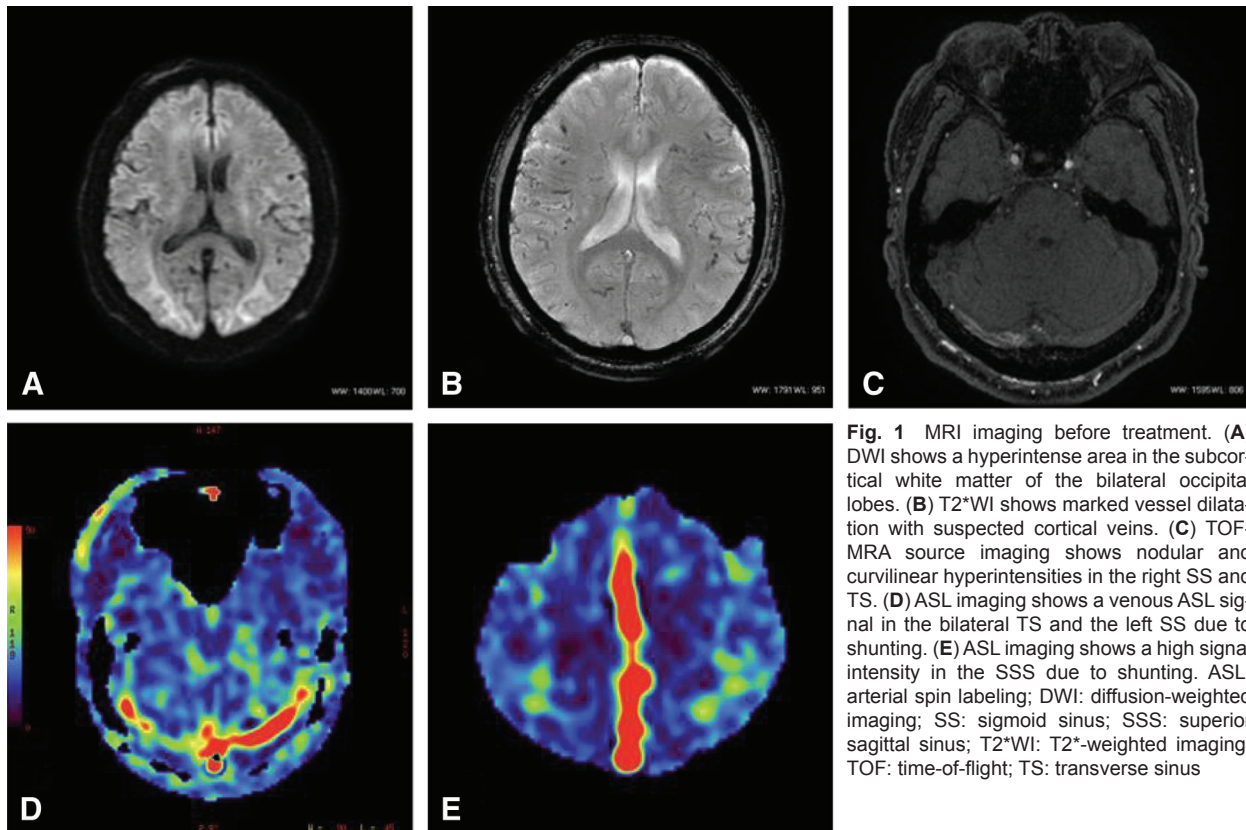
MRI imaging before treatment. (A) DWI shows a hyperintense area in the subcortical white matter of the bilateral occipital lobes. (B) T2*WI shows marked vessel dilatation with suspected cortical veins. (C) TOF-MRA source imaging shows nodular and curvilinear hyperintensities in the right SS and TS. (D) ASL imaging shows a venous ASL signal in the bilateral TS and the left SS due to shunting. (E) ASL imaging shows a high signal intensity in the SSS due to shunting. ASL: arterial spin labeling; DWI: diffusion-weighted imaging; SS: sigmoid sinus; SSS: superior sagittal sinus; T2*WI: T2*-weighted imaging; TOF: time-of-flight; TS: transverse sinus
